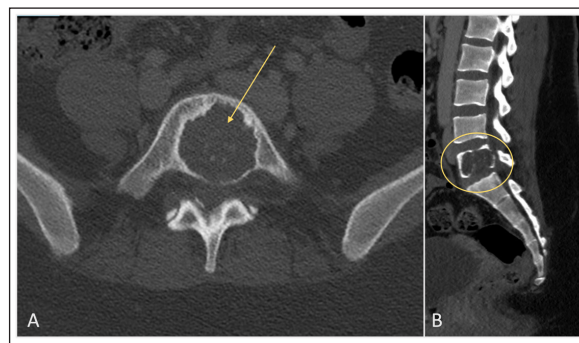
Preoperative images. Pre-op Computed tomography (CT) (A) axial and (B) sagittal showing osteolytic lesion in L5 vertebral body (yellow circle and arrow) with well-defined margin with moderate retropulsion of posterior wall and cortical thinning and break through. In addition, there was mild soft tissue component causing severe spinal canal stenosis.
